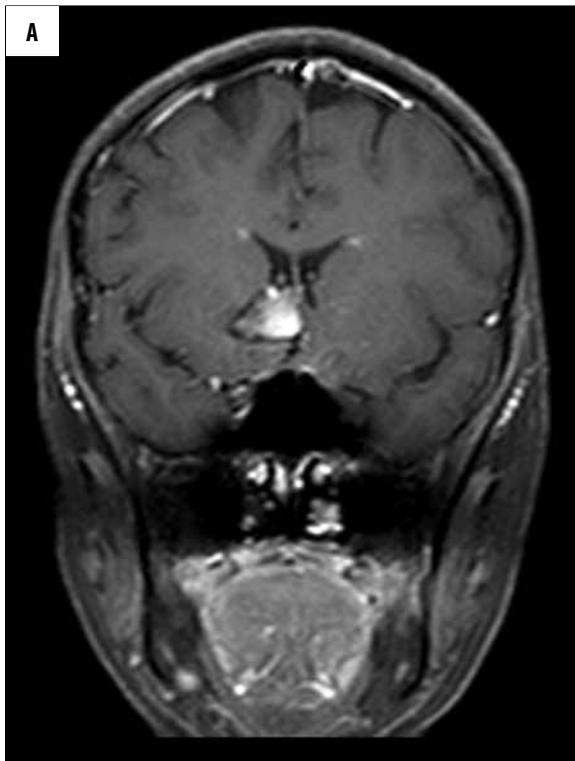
Head MRI + CM scan, T1-weighted image. (A) coronal plane, (B) sagittal plane. Central enhancement of hemangioma.
